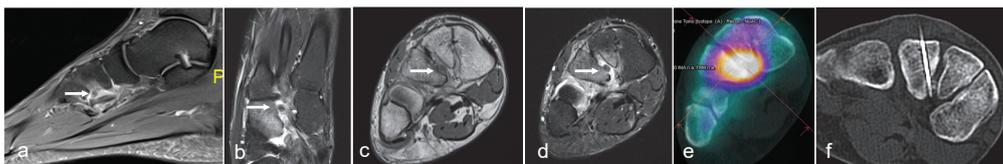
Sagittal (a) and axial (b) T2 fat-suppressed, coronal PD (c) and PD fat-saturated (d), SPECT CT (e) all showing osteoid osteoma of the lateral cuneiform (white arrows) treated with radiofrequency ablation (f).
